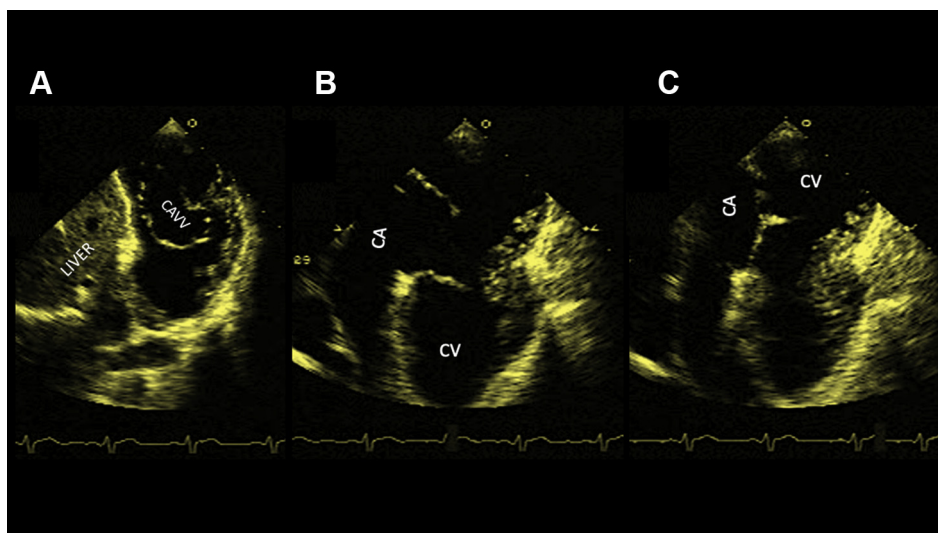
(A) Two-dimensional transthoracic echocardiogram in subcostal view showing atrioventricular connection with the common AV valve. (B, C) Single morphologic right ventricle with the common AV valve in diastole and systole with double outlet. AV, atrioventricular valve; CA, common atrium; CAVV, common atrioventricular valve; CV, common ventricle.
